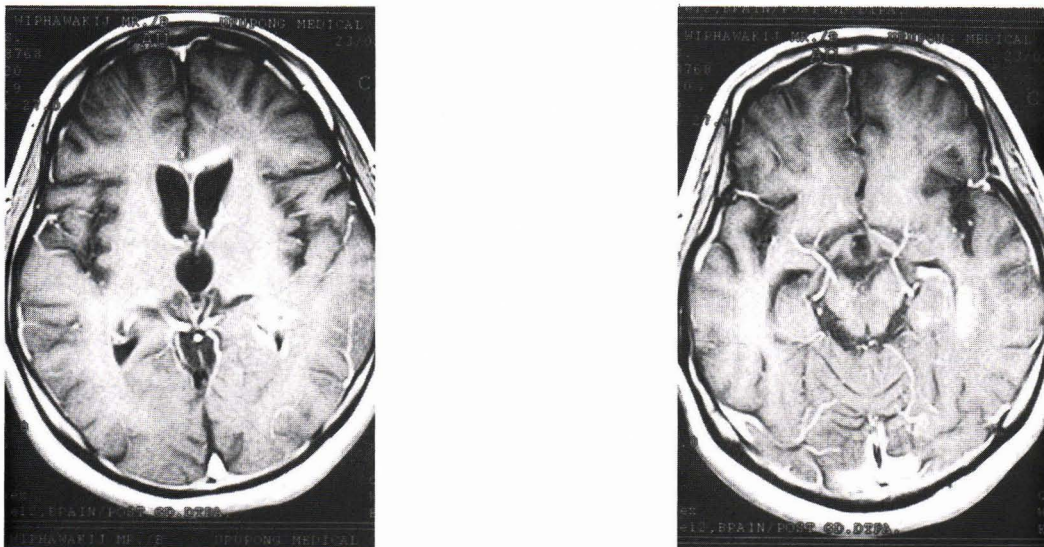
MRI of the brain (A) shows multiple enhancing lesions at corpus callosum, bilateral frontal horns and left occipital horn of lateral ventricles without pineal involvement. (B) Lesions at left temporal horn of lateral ventricle are noted. Suprasellar region is unremarkable.
